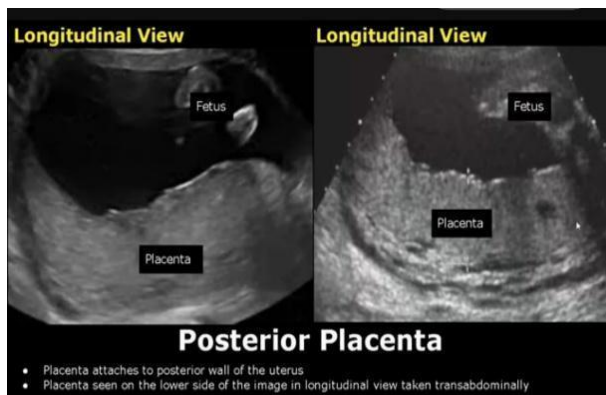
Ultrasonographic image of posterior placenta Dr. Sam's imaging library. Ultrasound image of placental position; posterior placenta [23.10.2022].
